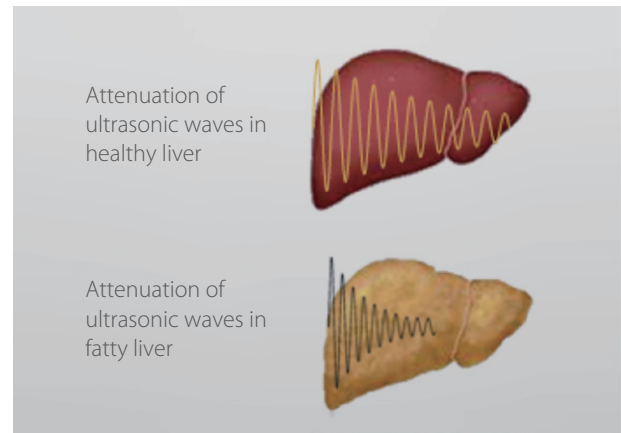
Impact of Fatty Liver on Ultrasonic Wave Attenuation
